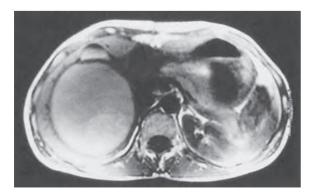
MRI scan (T_2 weighted) of a large right adrenal phaeochromocytoma. This lesion was originally referred as a possible hepatic cyst.
